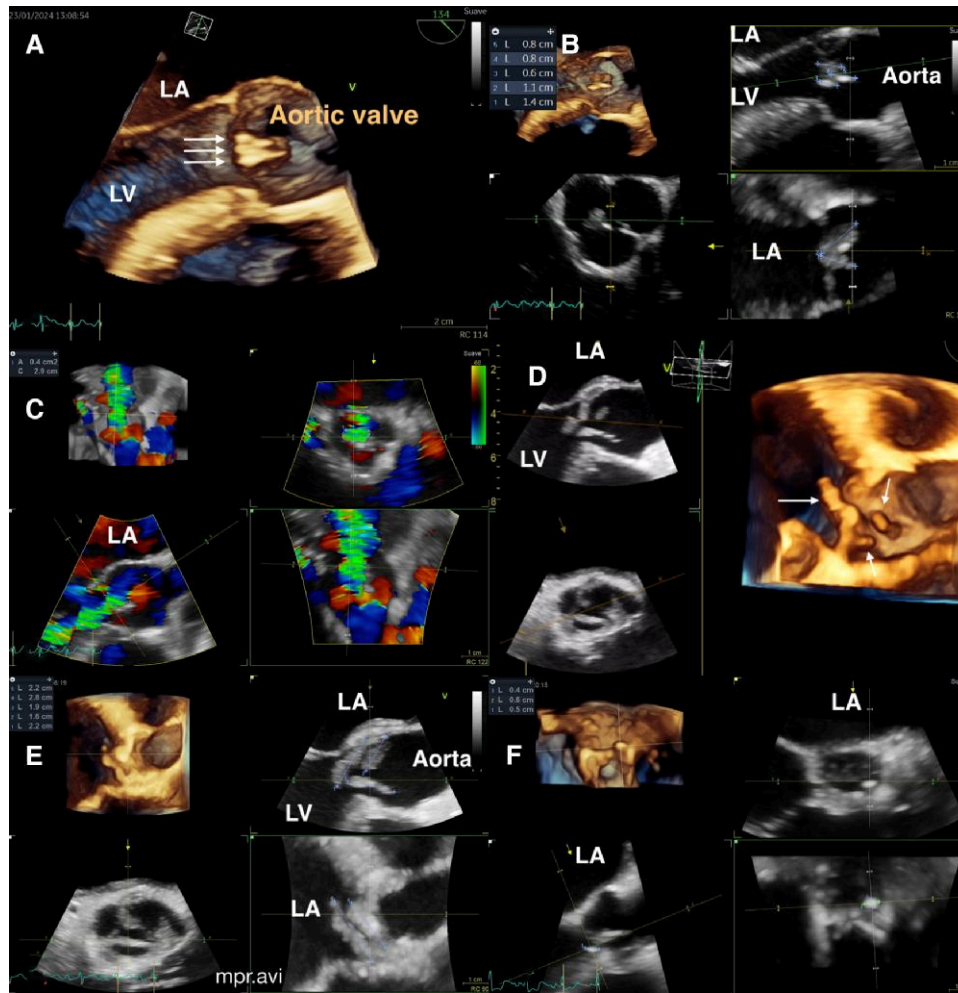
Vegetations. (A) TOE at mid-oesophageal level acquired at 134°, volume rendering. Long-axis view of the native aortic valve shows three filamentous vegetations (white arrows). (B) MPR of the previous image, locating vegetations on three leaflets, with the non-coronary cusp-dependent one being the largest at 14 mm (bottom right quadrant). (C). Colour Doppler MPR of the same case, determining the area of major regurgitation jet at 0.4 cm² in the short-axis view (top right quadrant). (D) TOE at mid-oesophageal level acquired at 120°, volume rendering. Section and superior view of the native aortic valve shows multiple vegetations (white arrows) distorting the valve. (E) MPR of the previous image locates vegetations on all three leaflets and identifies the largest vegetation of 28 mm embedded in the left coronary cusp. (F) TOE at mid-oesophageal level acquired at 45°, MPR of the native aortic valve, showing a small ovoid vegetation of 6 mm maximum diameter on the right coronary cusp. LA, left atrium; LV, left ventricle.
